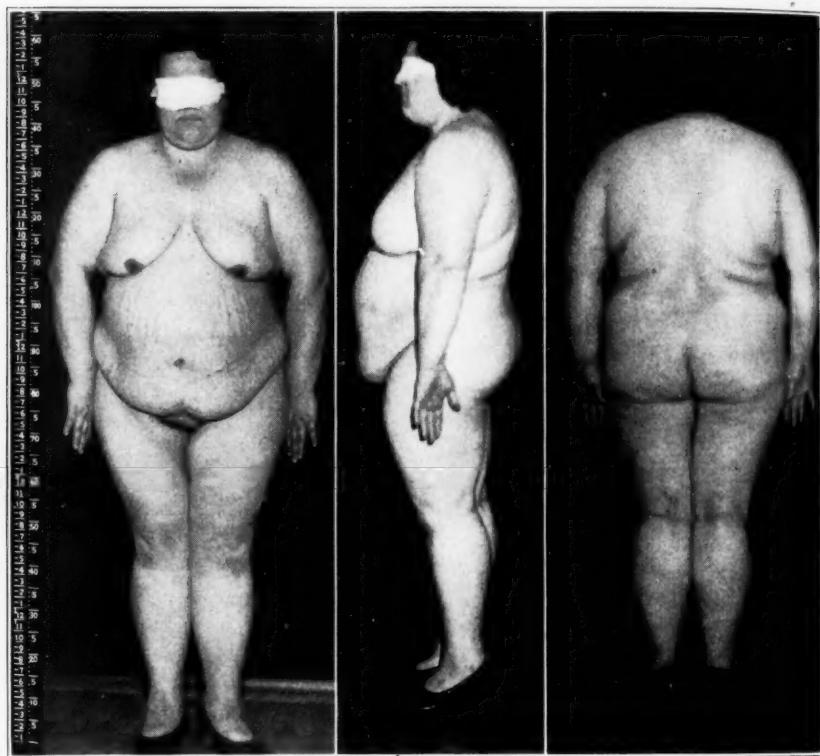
Photographs of the patient the roentgenogram of whose skull is shown in figure 2.
